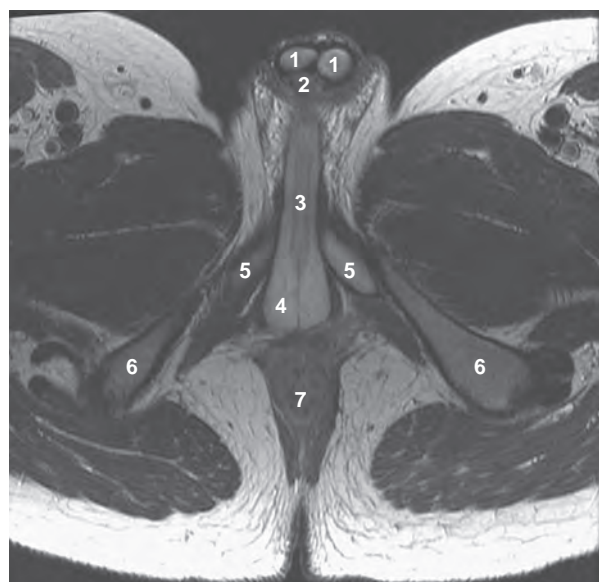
Axial T1-weighted MRI of male pelvis. 1, Corpora cavernosa in cross section; 2, corpus spongiosum in cross section; 3, corpus spongiosum in perineum; 4, bulbospongiosus muscle, which facilitates urine or seminal fluid expulsion from bulbar urethra; 5, crura of corpora cavernosa—note divergence of crura as they insert on pubic bone; 6, ischial tuberosities; 7, rectum.
